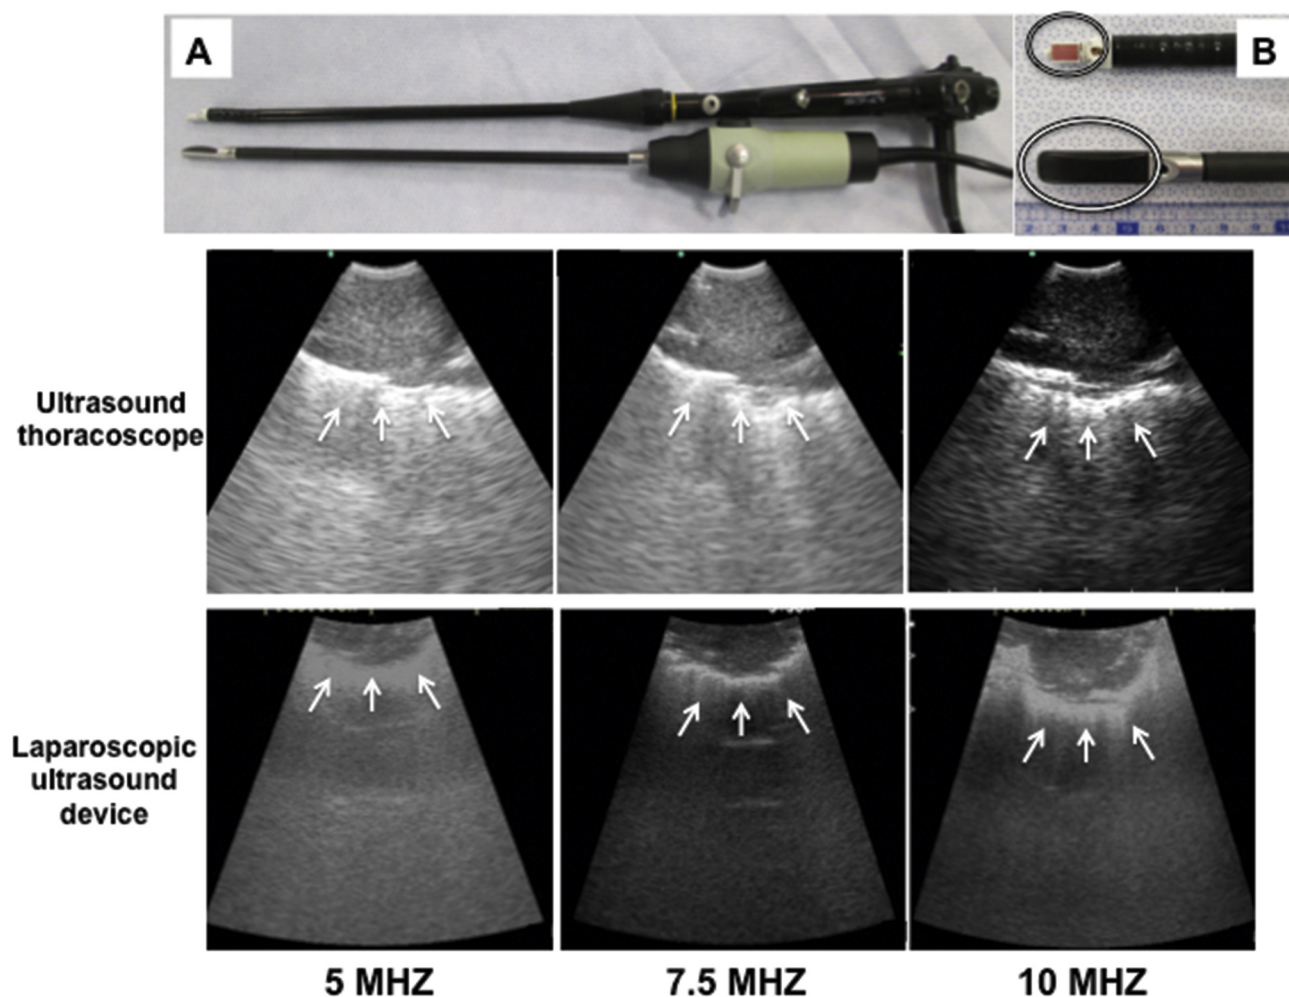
(A) Comparison between prototype ultrasound thoracoscope (XLTF-UC180 [top]) and laparoscopic ultrasound probe (8666-RF [bottom]). (B) Comparison of ultrasound thoracoscope probe size (top) and laparoscopic ultrasound probe size (bottom). The laparoscopic ultrasound probe is bigger than the ultrasound thoracoscope probe. (C) Comparison of image quality of ultrasound thoracoscope (top panels) and laparoscopic ultrasound (bottom panels) for a solid nodule at different frequencies: left to right, 5 MHz, 7.5 MHz, and 10 MHz. The ultrasound thoracoscope consistently produced clearer images (arrows).
